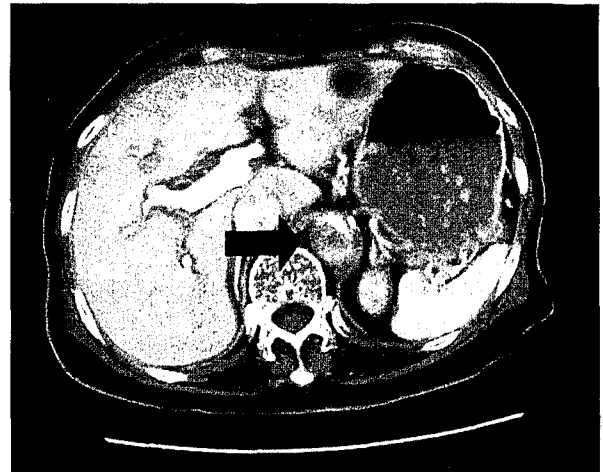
An abdominal CT scan shows nearly total occlusion of the abdominal aorta. The true lumen is compressed by the false lumen and the false lumen is filled with thrombus.
